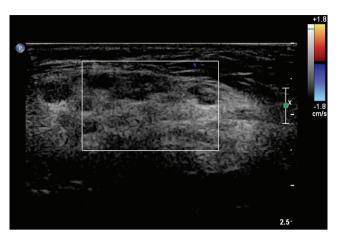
Doppler US shows no evident blood flow.
